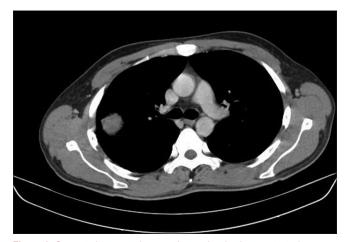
Computed tomography scan thorax showing lung metastasis
